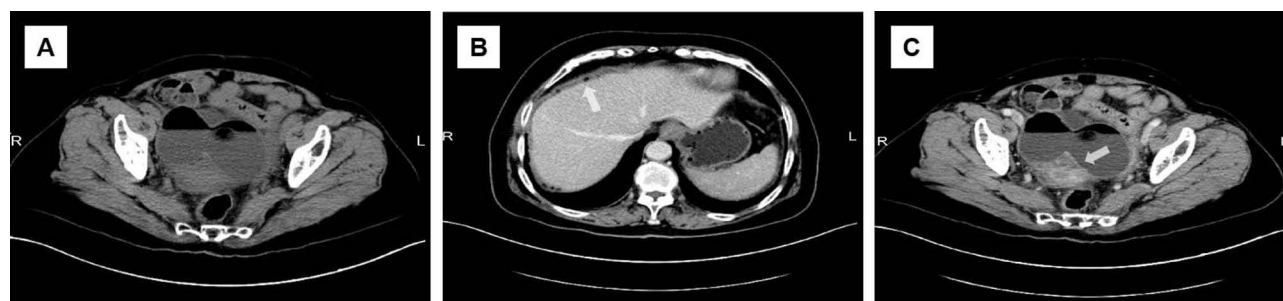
Enhanced abdominal CT examination results. (A) An irregular low-density pelvic lesion with visible lipid-fluid levels. (B) Unclear surrounding space with soft tissue density around the liver area (indicated by the arrow). (C) Contrast-enhanced CT shows obvious enhancement at the edge (indicated by the arrow).
